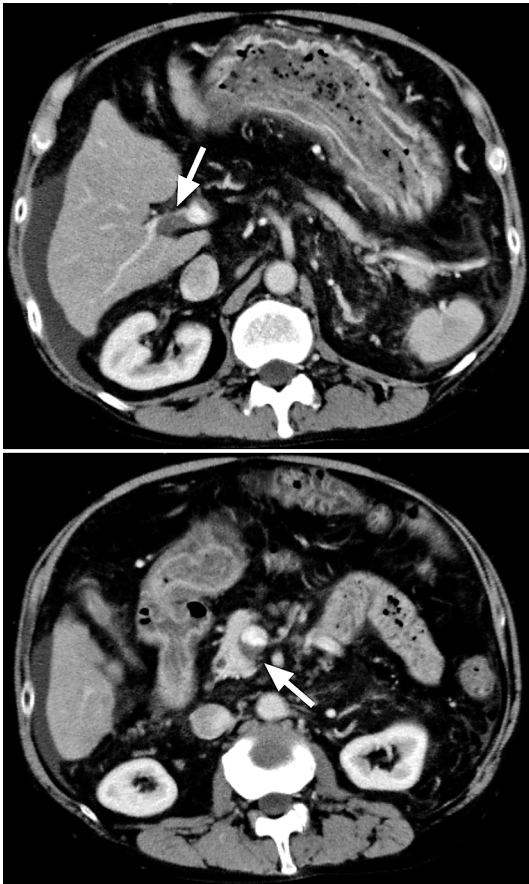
Computed tomography on the day the patient sustained rupture of esophageal varices. The thrombus in the portal vein (upper panel) extended to the upper mesenteric vein (lower panel). The irregular surface of the atrophic liver was compatible with liver cirrhosis.
